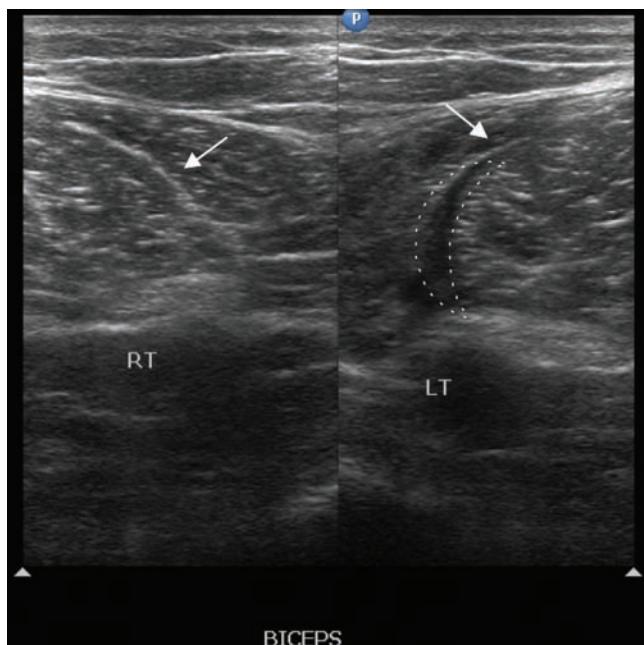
Ultrasound scan of a grade 2 (according to Pecten) biceps femoris injury. Transverse gray-scale ultrasound images over the proximal part of the biceps femoris muscle: on the right, the scan demonstrates the musculotendinous junction partial tear as an area (dotted shape) of low echogenicity adjacent to the reflective aponeurosis (arrow); on the left, the contralateral normal musculotendinous junction is depicted.
